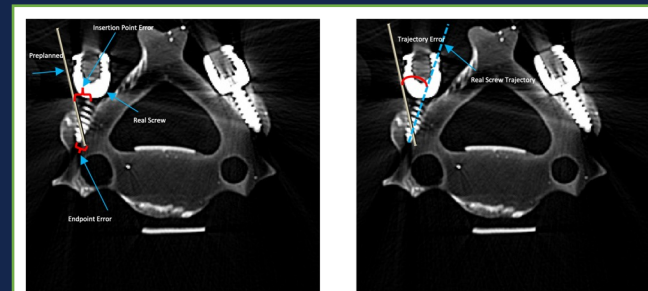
Pre-insertion and post insertion CT images were fused. A) The insertion point and endpoint distance error was measured as the Euclidian distance between the corresponding points of the preplanned trajectory and real screw. Multiple views of the reconstructed 3D digital spine model with preplanned trajectories. B) The trajectory angle error was measured as the angular difference between the preplanned trajectory and the physical screw path
